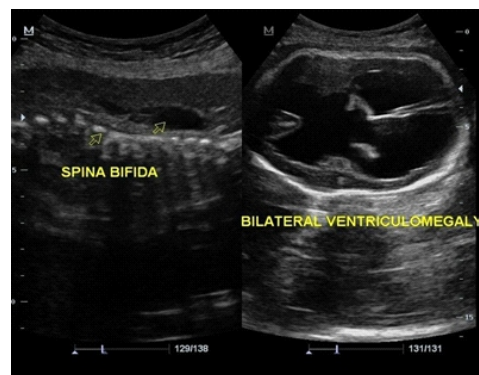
Ultrasound images of fetal spine and fetal head. Image on left side demonstrate spina bifida in fetus. Image on right side demonstrate severe bilateral ventriculomegaly.
